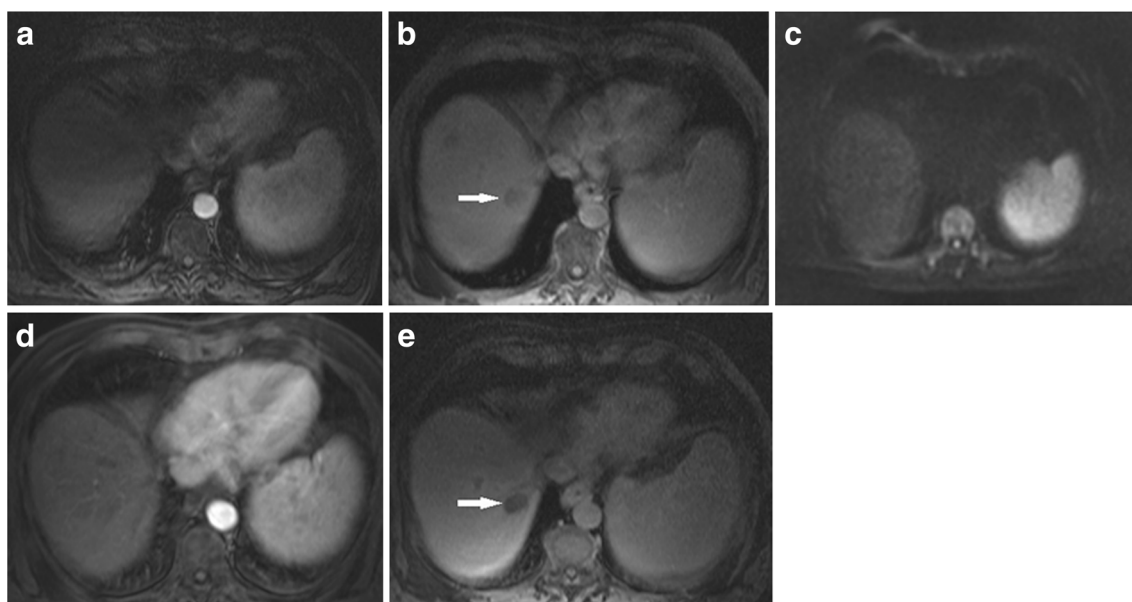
MR images of hepatocellular nodule that did not progress to hypervascular HCC in a 65-year-old man with hepatitis B virus-related cirrhosis. No focal lesions are detected on arterial phase image (a). HBP image shows a hypointense lesion (arrow) (b) that does not show
